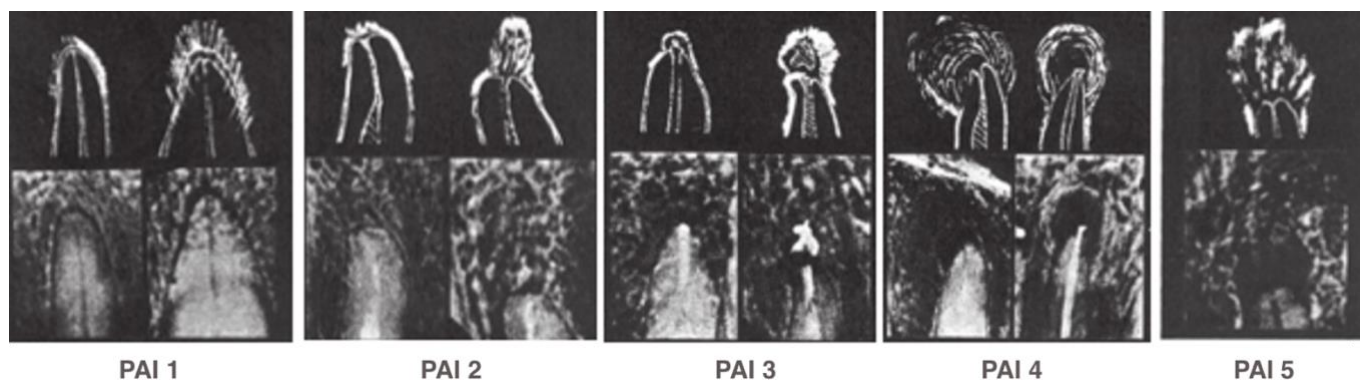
Periapical Index (PAI) categories
